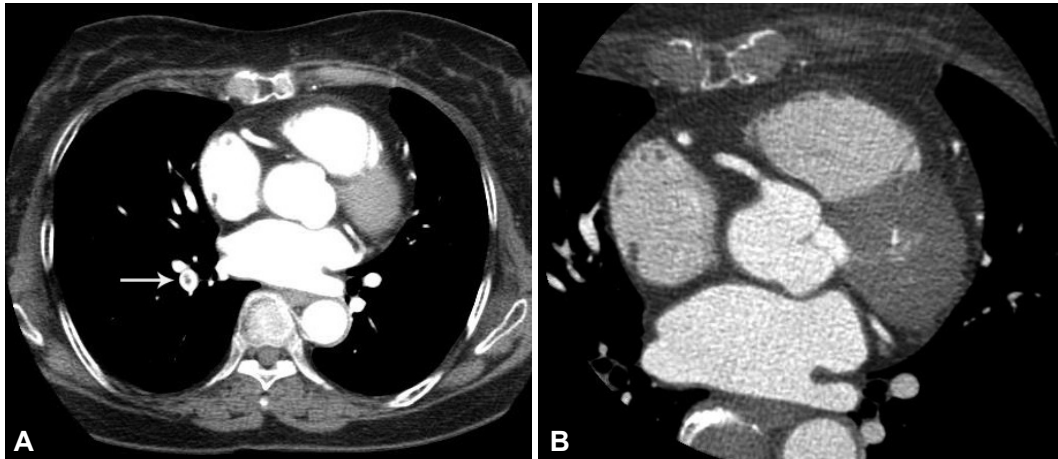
Diagnostic delay in a 62-year-old female patient with acute pulmonary embolism. This patient presented with nonspecific acute chest pain. As atypical chest pain of non-urgent cause was the initial impression, dedicated coronary CT angiography was performed 3 days later. Coronary artery assessment was negative. A: segmental pulmonary embolism (arrow) is noted in posterior segmental pulmonary artery of the right lower lobe on a trans-axial CT image at the level of left atrium. B: note that this finding is not identified on a trans-axial CT image with small field of view. This case shows the importance of using a wide field of view image when interpreting dedicated coronary CT angiography.
